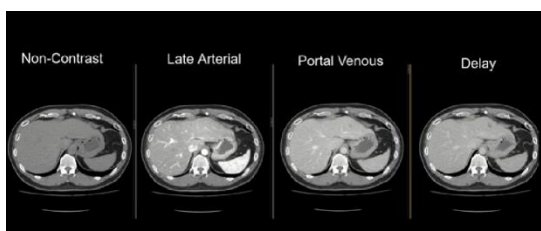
Triphasic of contrast liver CT
